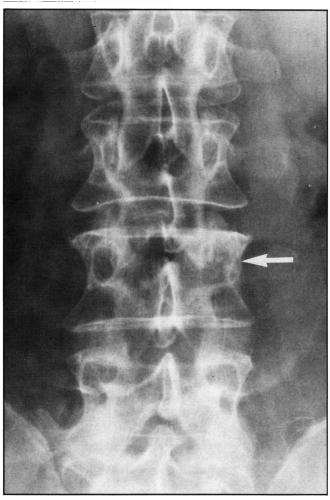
AP Radiograph of lumbar spine showing pedicle erosion (arrow) ("Winking Owl Sign").
